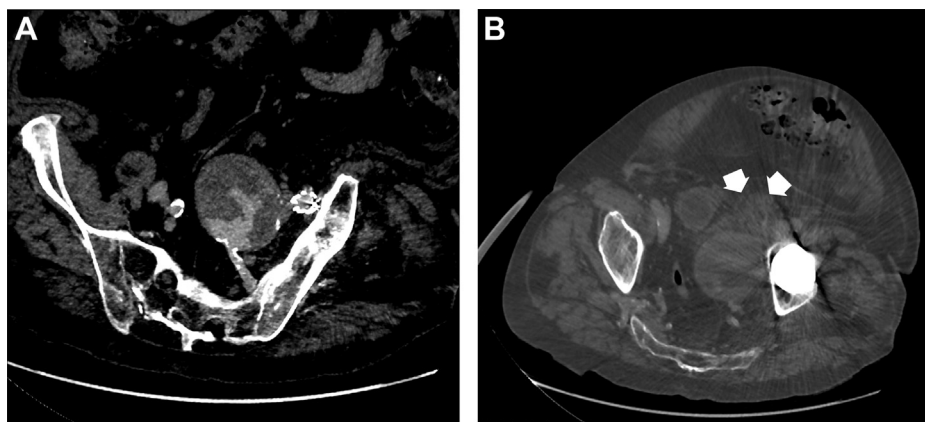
(A) CT scan reconstruction showing a 72-mm aneurysm with contrast enhancement via the collateral branches of the internal iliac artery. (B) Retroperitoneal perianeurysmal hematoma (arrow).
